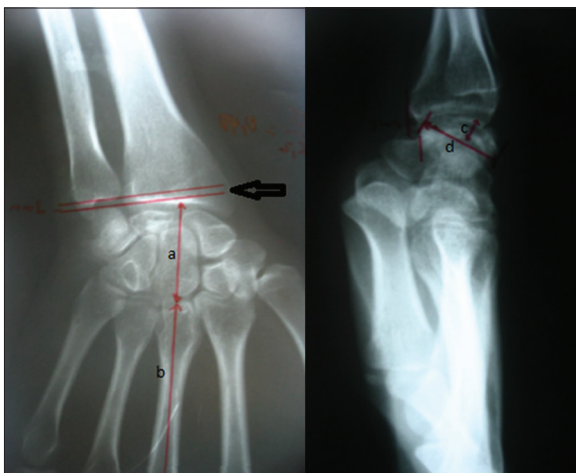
A-P and lateral X-rays of the wrist showing kienbock's disease stage IIIb with measurement of: Ulnar variance: negative (black arrow) a/b: (height of carpe/height of central metacarpal) shows collapse of central column c: height of collapsed lunate d: diameter of lunate
